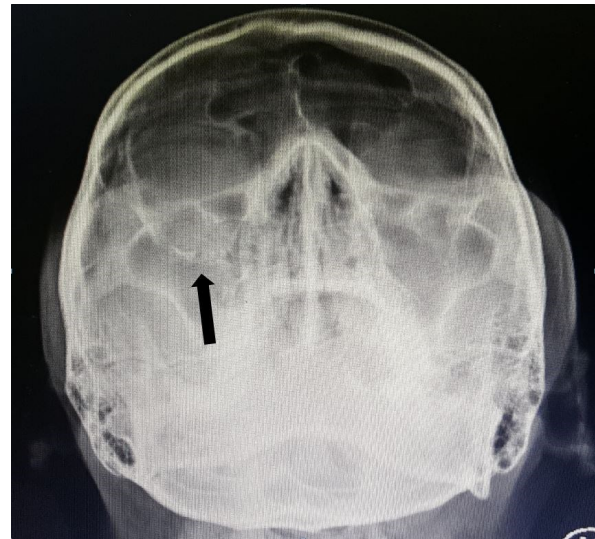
30 degree occipito-mento view radiograph displaying comminuted fracture (black arrow) of the right inferior orbital wall.
